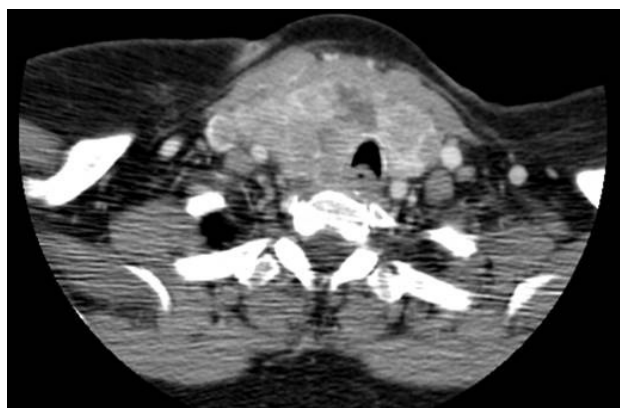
CT scan performed prior to thyroidectomy. Enlarged and heterogeneous thyroid gland, particularly involving right lobe. Thyroid gland extends inferiorly into superior mediastinum. Trachea is shifted to the left.
